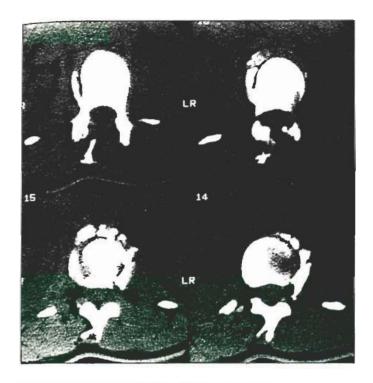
Complex vertebral fracture. Axial CT through the T12 vertebral body (figure 11) shows numerous fragments of the vertebral body anteriorly and to the left. There is a unilateral naked facet sign on the left.
